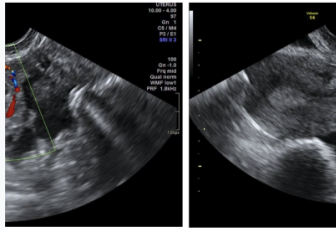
Figure 1. Ovarian Cyst rupture. A/ Endovaginal sonography : Heterogeneous round structure on the right ovary with a peripheral "ring" color Doppler hypersignal Heterogeneous echogenic fluid collection in the pouch of Douglas (yellow line)
